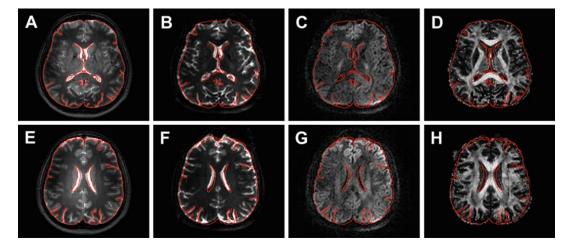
Examples of misalignment between different image types. *Panels* (a) and (e) show high-resolution T2-weighted images with the contour of the brain outlined
